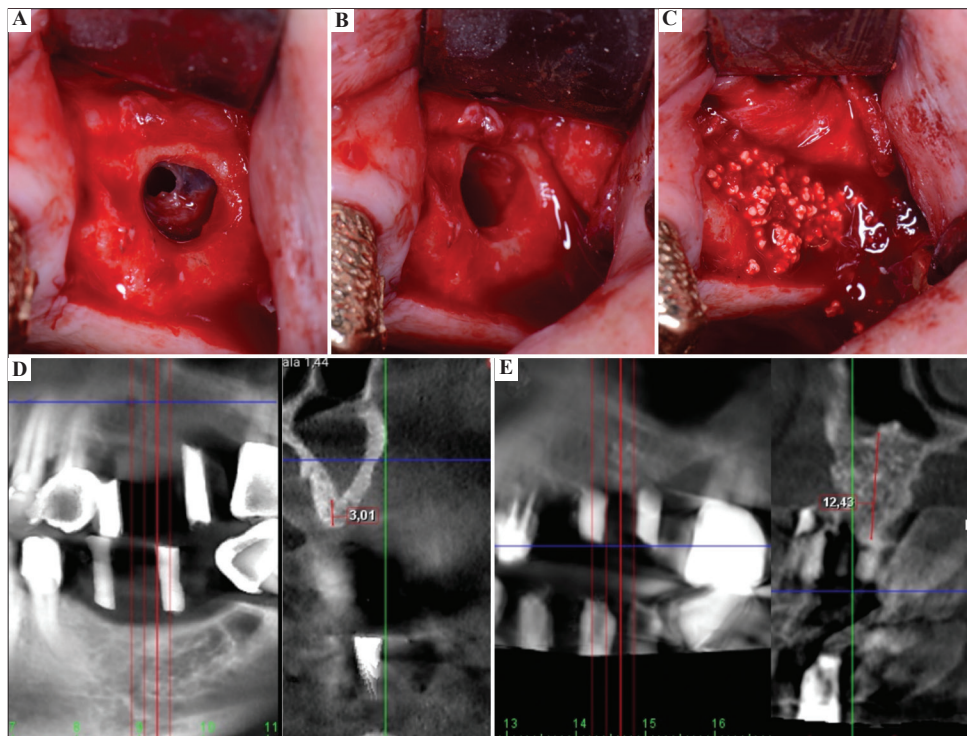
Patient no. 3. (A) A type I perforation of the Schneiderian membrane occurred. (B) Once the detachment was completed, two leukocyte and platelet-rich fibrin (L-PRF) membranes were overlapped to seal it. (C) The subsinusoidal cavity was filled with particulate bone graft and the antrostomy was sealed with two L-PRF membranes. (D) Initial cone-beam computed tomography (CBCT). (E) CBCT at 6 months post-surgery.
